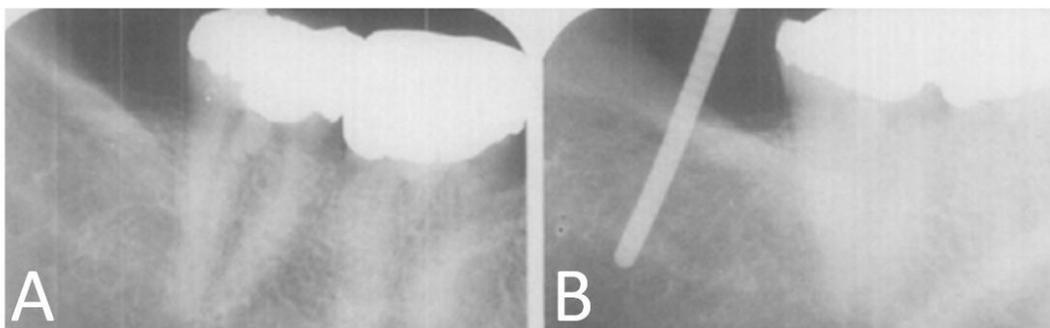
Radiographic image of the lower left posterior mandibular region, from a case of atypical facial neuralgia. As noted in the left image(A), there is no visible indication of an abnormality. However, the right image shows the same the area after a metal probe had been inserted into an existing bone cavity to a depth of 14 mm(B)[Ref.: Ratner et al., 1979].
